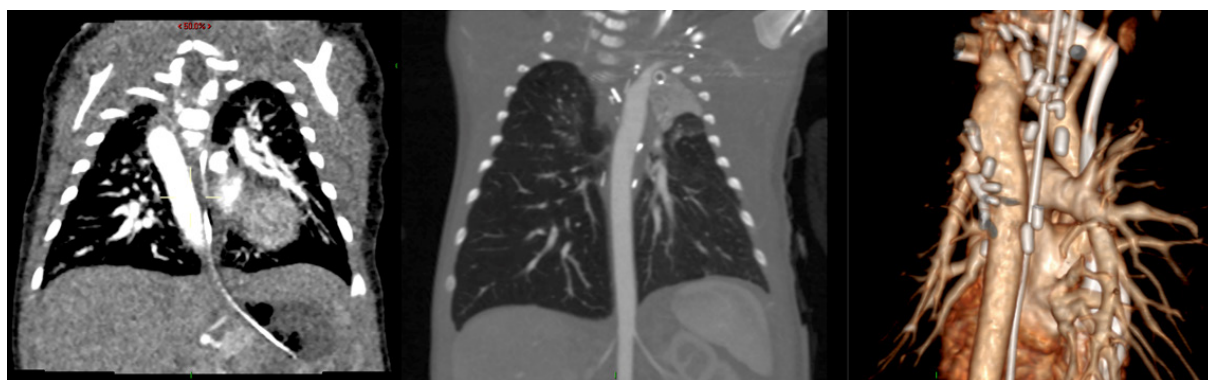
Computed tomography scan of a neonate with circumflex aorta with left aortic arch and critical arch hypoplasia: (left) descending aorta location to the right side of the spine; (middle) normalization of the course of the descending aorta following posterior aortic translocation; (right) 3D reconstruction of the aortic arch following surgery
